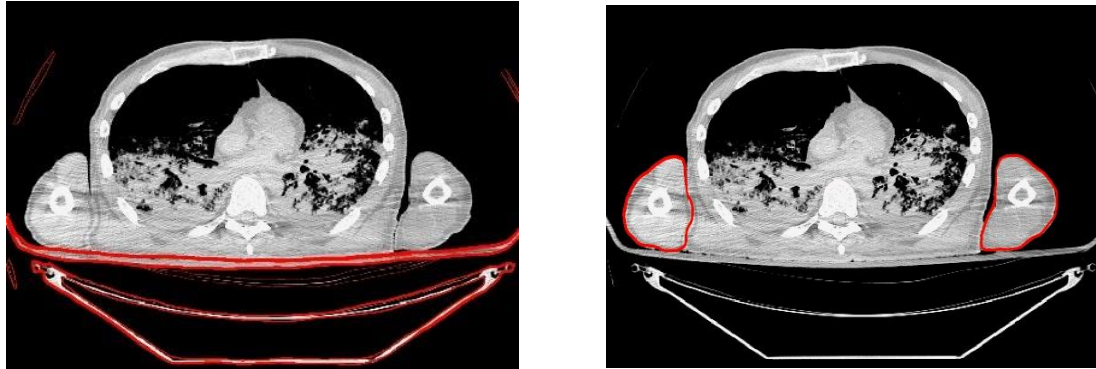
Transverse slice through the centroid of 8th thoracic vertebra in subject 00606M. (a) Torso with cavities removed masked in red. (b) Torso including arms and the CT bed masked in red.
